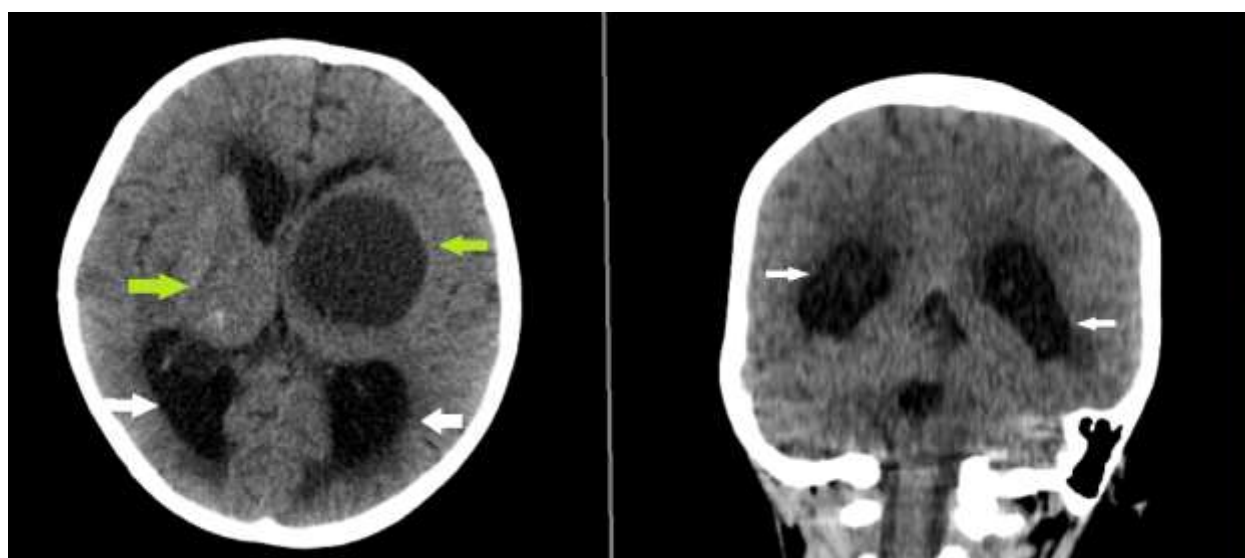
CT brain axial image with coronal reformat showing re-demonstration of large tumor centered over bilateral basal ganglia. Interval increase in the size of cystic component of the tumor involving left basal ganglia and internal calcifications in part of lesion centered on right basal ganglia (green arrows). Interval increase in hydrocephalus (white arrows).
